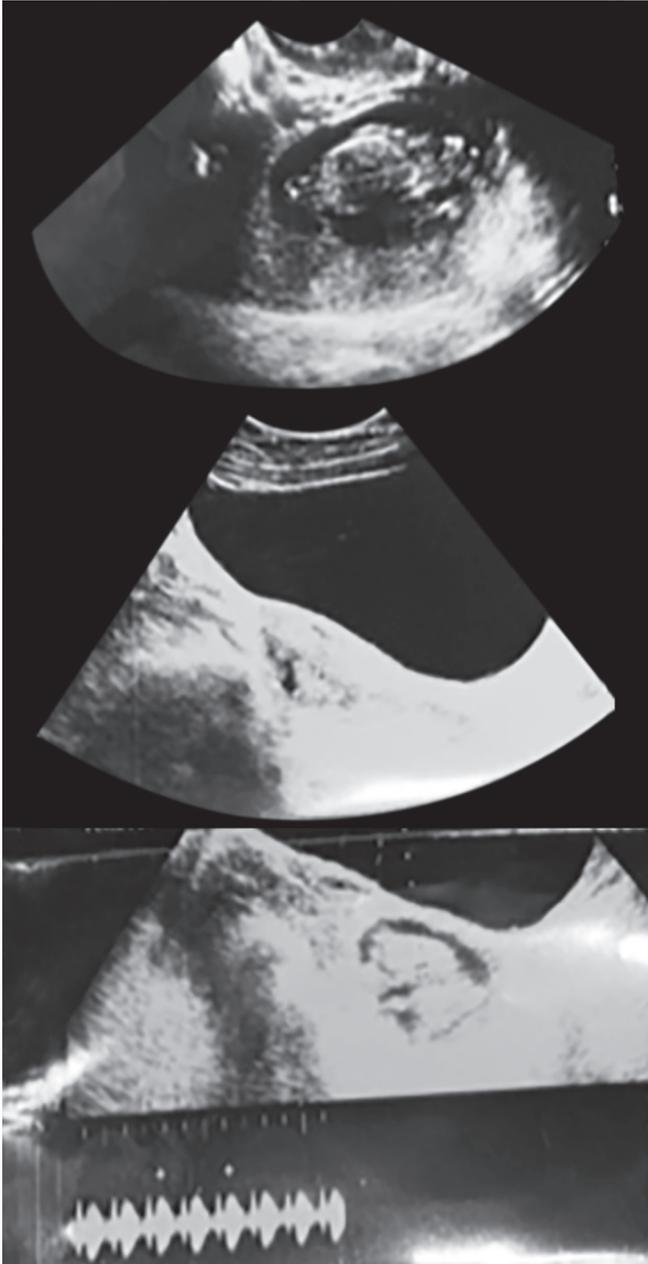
Ultrasound films showing the gestational age of the fetus and its location
